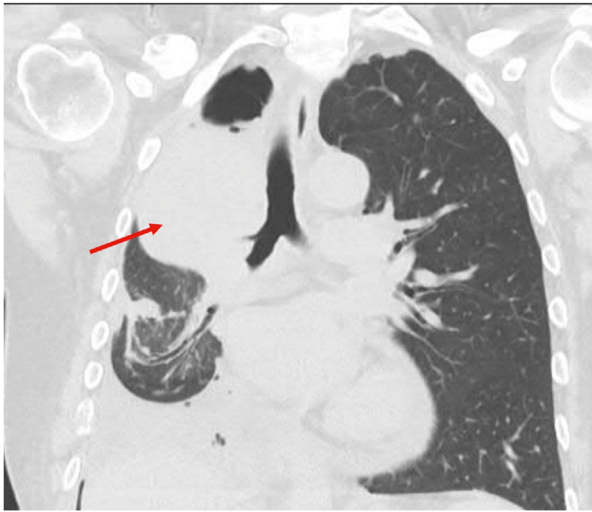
CT chest (coronal plane) showing mass-like consolidation in the right upper lung (arrow).
